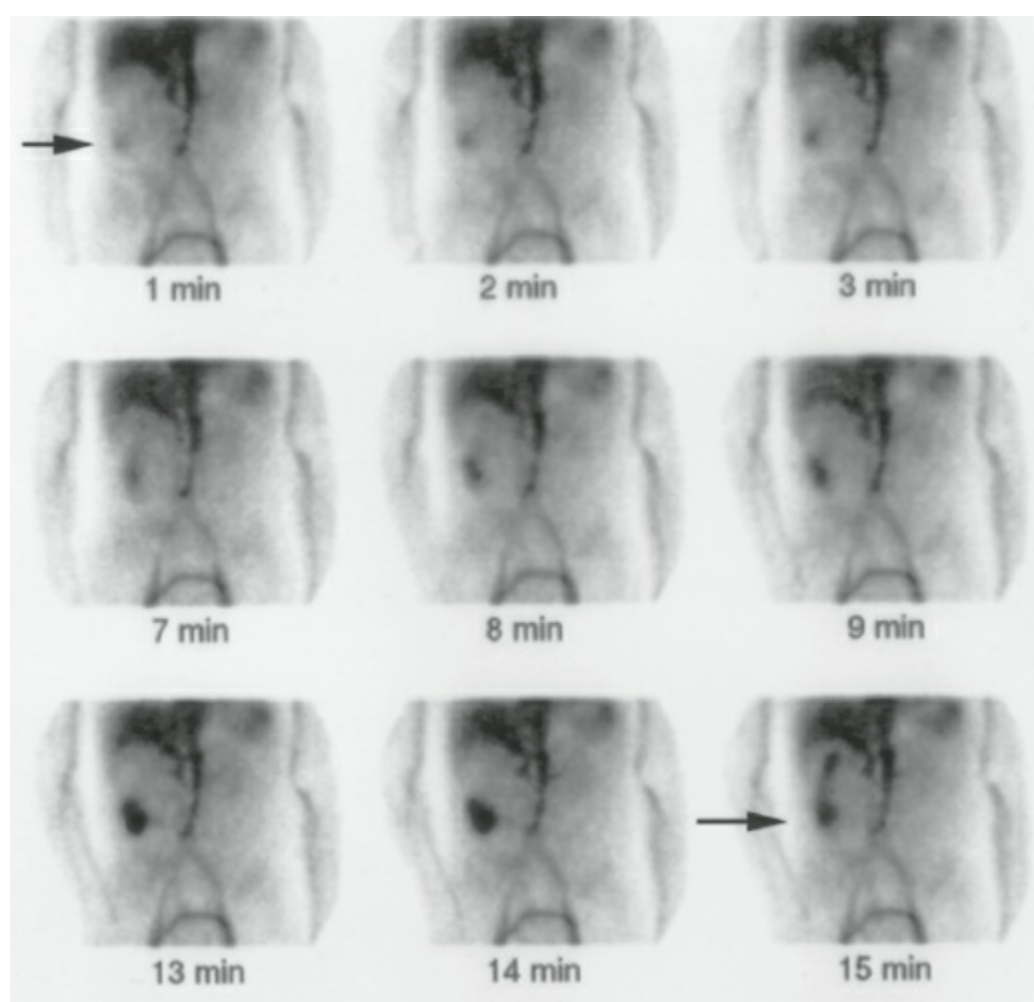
Cine- ^{99}Tc erythrocyte scintigraphy showing extravasation of isotope in the right colon. Only a small portion of the image set is shown. Arrows point to accumulation of isotope in right colon. Bleeding was due to delayed hemorrhage following endoscopic polypectomy.
